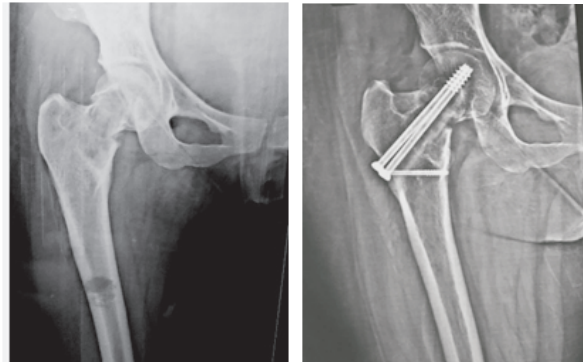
Pre-operative & Post operative X-ray
